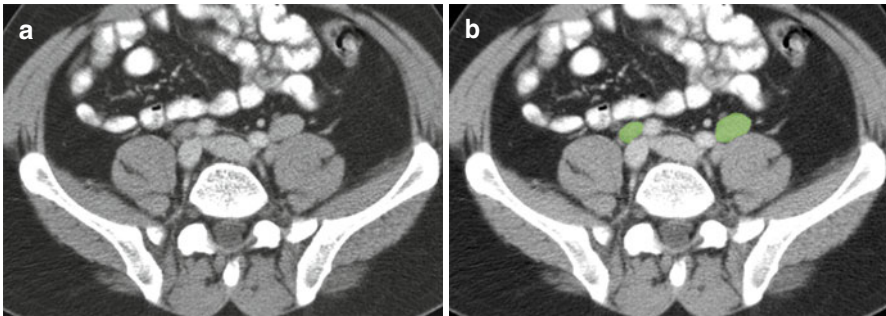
(a, b) Axial CT image shows bilateral common iliac lymph nodes (*green*)
